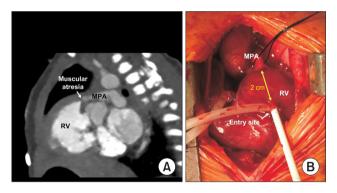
The morphology of right ventricular outflow tract (RVOT) on preoperative computed tomography and the operative field. (A) Preoperative computed tomography revealed the muscular nature of the atretic segment. (B) An intraoperative photograph showed the entry site on the right ventricle (RV) free wall. MPA, main pulmonary artery.
